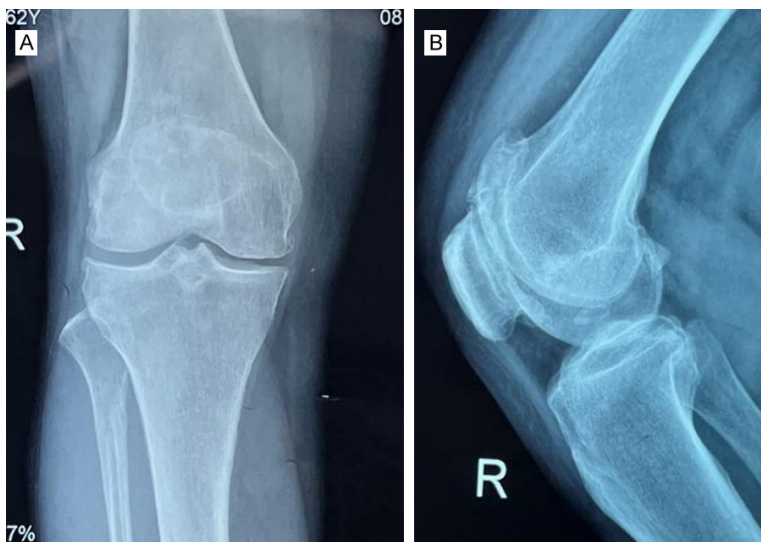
Kellgren-Lawrence grade I-III knee osteoarthritis. A. Coronal X-ray of right knee. B. Sagittal X-ray of right knee.
